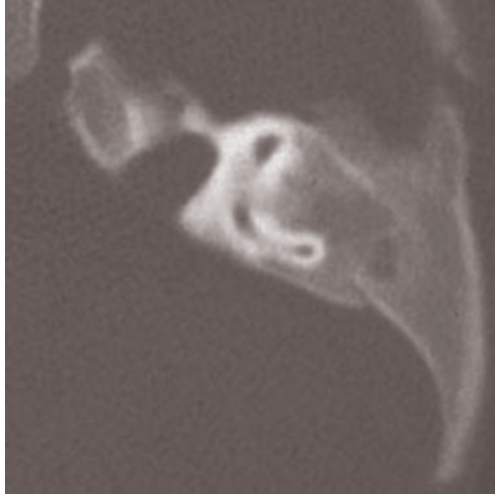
Axial CT scan. Dilation of the internal auditory canal (reprinted from Calzolari F. et al. *Malformazioni dell' orecchio nelle anomalie congenite cranio-facciali. Rivista di Neuroradiologia* 2003; 16: 411–420 [36]. With permission of Edizioni del Centauro).
